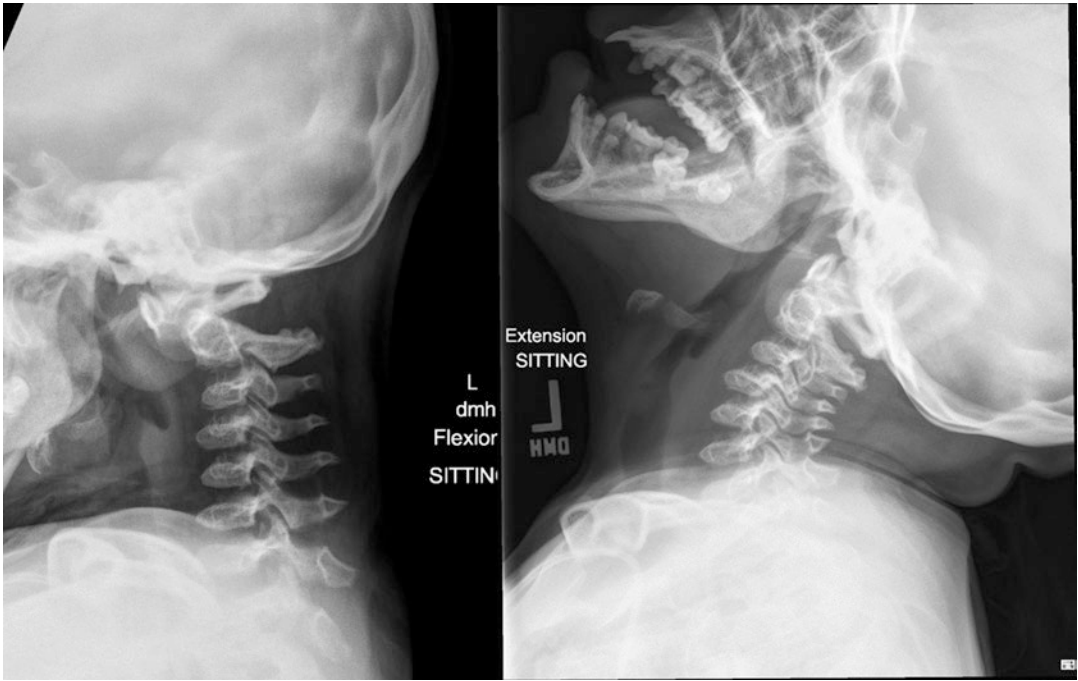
Atlantoaxial (C1–2) cervical instability. Flexion-extension radiographs of a patient with Morquio syndrome showing large anterior subluxation of C1 on
